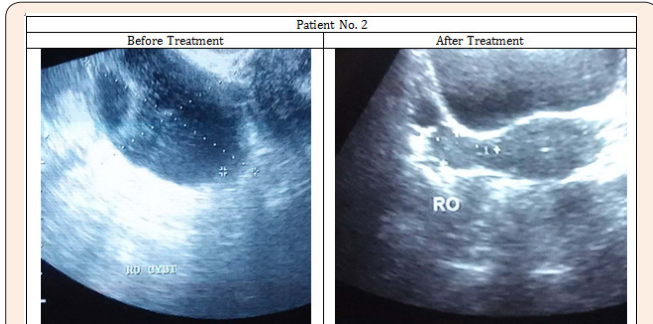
Images of Ultra-sonography of the patient No. 2 showing removal of the cyst from right ovary.
